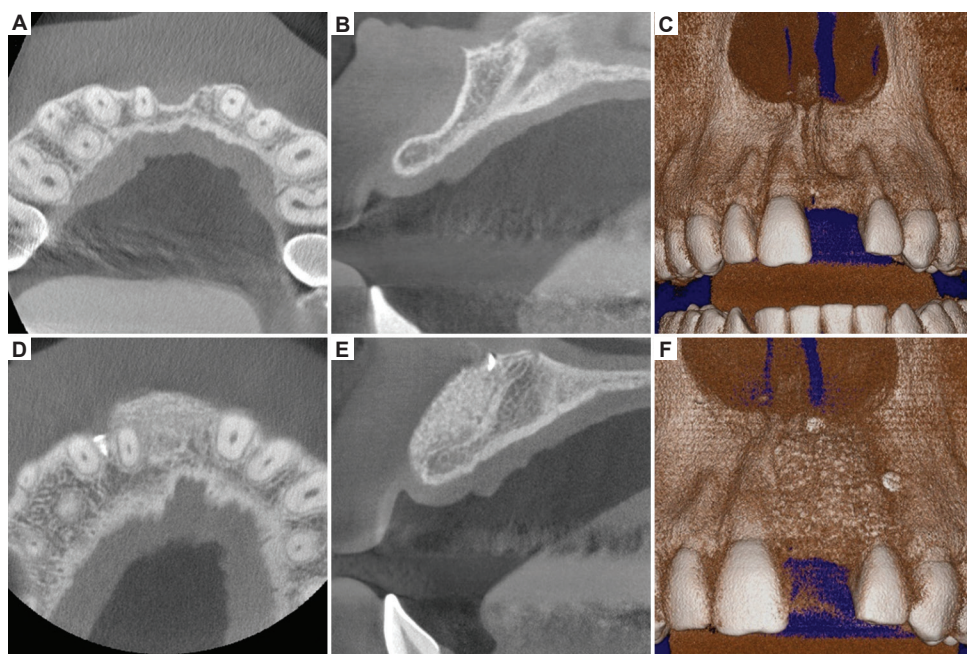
Comparison of baseline and follow-up cone-beam computed tomography volumes. (A) Baseline axial slice. (B) Baseline cross-sectional slice. (C) Baseline volume rendering. (D) Axial slice 6 months following the procedure. (E) Cross-sectional slice 6 months following the procedure. (F) Volume rendering 6 months following the procedure.
